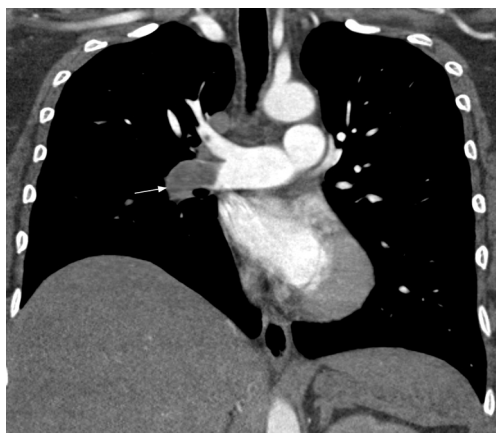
Coronal CT pulmonary angiography image shows a larger thrombus in the right interlobar artery with complete occlusion and vessel cutoff (arrow).
